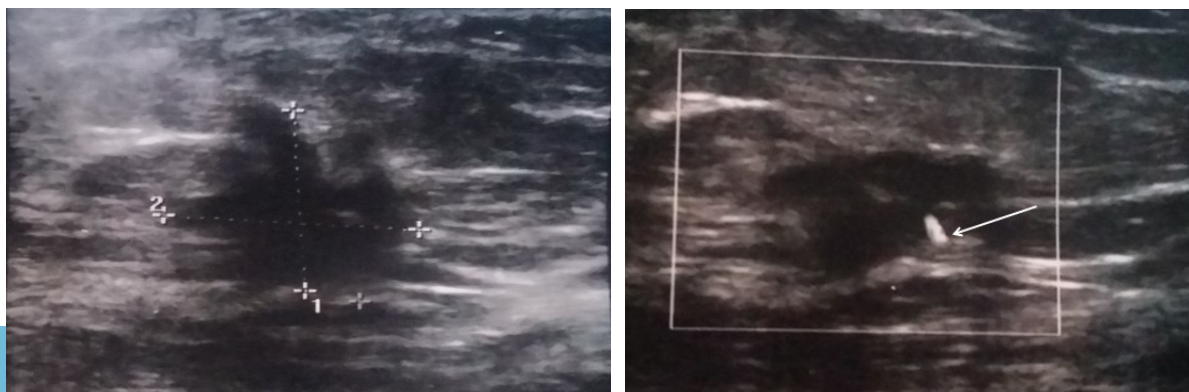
On the left: subcutaneous hypoechoic lesion with irregular margins infiltrating the adjacent tissues. On the right: single pedicle entering the mass at the periphery (white arrow) in color Doppler.
